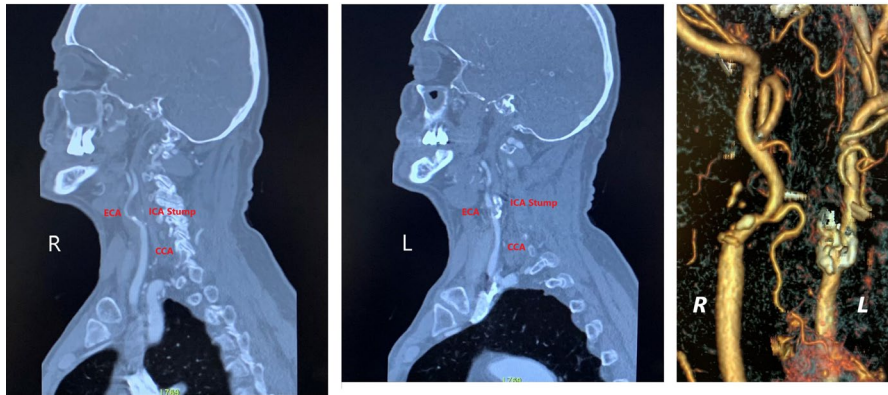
CTA showing occluded ICA bilaterally with ECA high-grade stenosis. CCA, Common carotid artery, ECA, External carotid artery, ICA, Internal carotid artery
